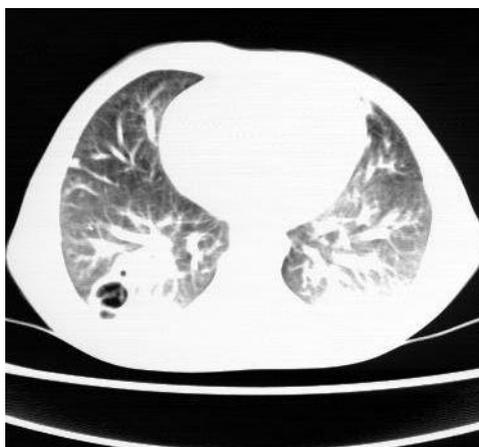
CT scan shows cavity in right lung (Case 1)
